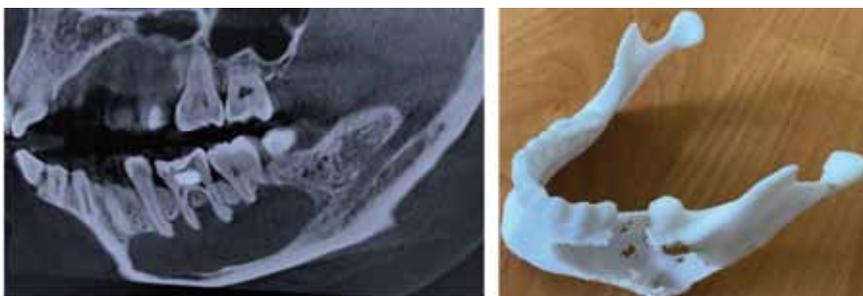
X-ray and lithographic model of the lower jaw of the affected tumor
